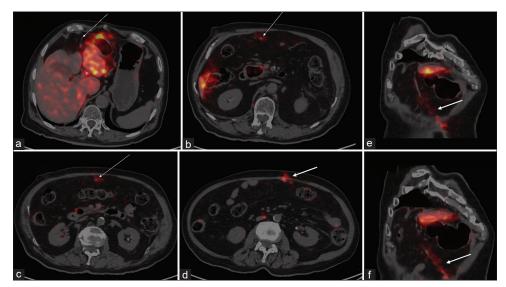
Post-TARE reconstructed PET/CT images in transaxial (a-d) and coronal (e and f) sections reveal mild deposition of Y-90 microspheres in the hepatic falciform artery (white arrows). TARE: Transarterial radioembolization, PET/CT: Positron emission tomography/computed tomography
